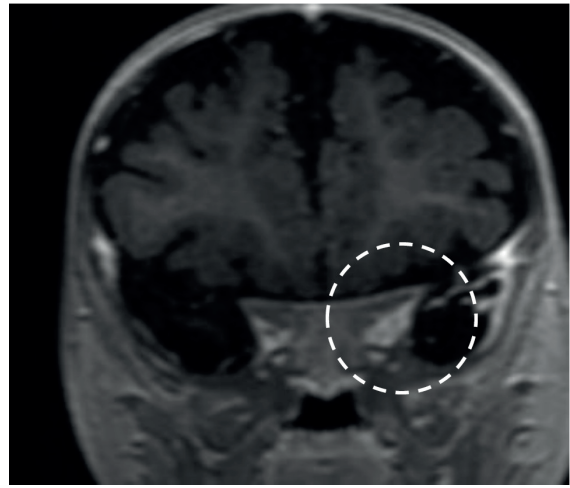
Coronal contrast enhancing T1W MRI shows asymmetric contrast enhancement at the left orbital apex.
